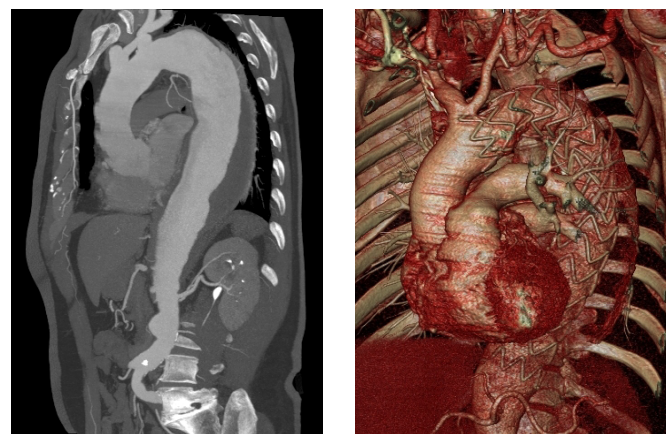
A, Computed tomography (CT) scan of thoracoabdominal aneurysm from left subclavian artery through 1.5 cm proximal to the celiac artery. B, A control CT scan revealed an intact endovascular stent and intact aortic tissues on the 30th postoperative day.
